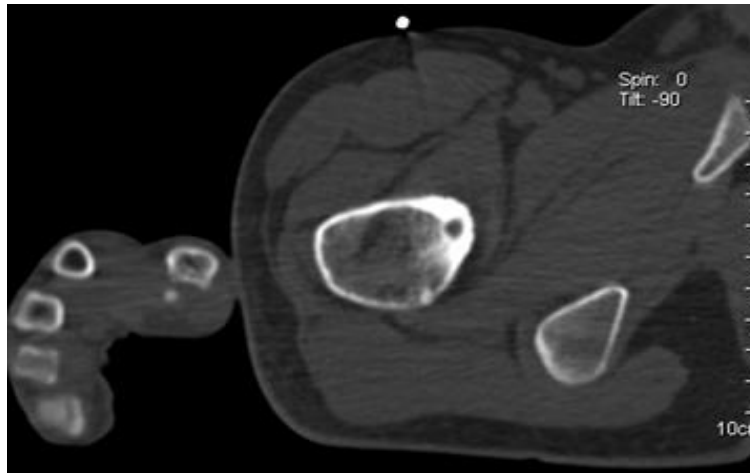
Case 3 Male, 18 years old, osteoid osteoma of proximal femur, 2017-2-21, preoperative CT axial position
